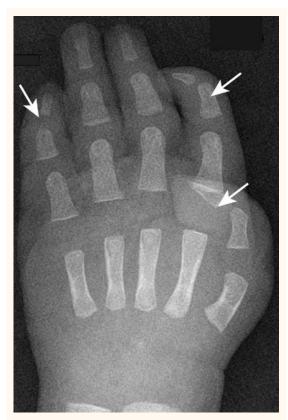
X-ray of the left hand showing camptodactyly (bent fingers and thumb).
